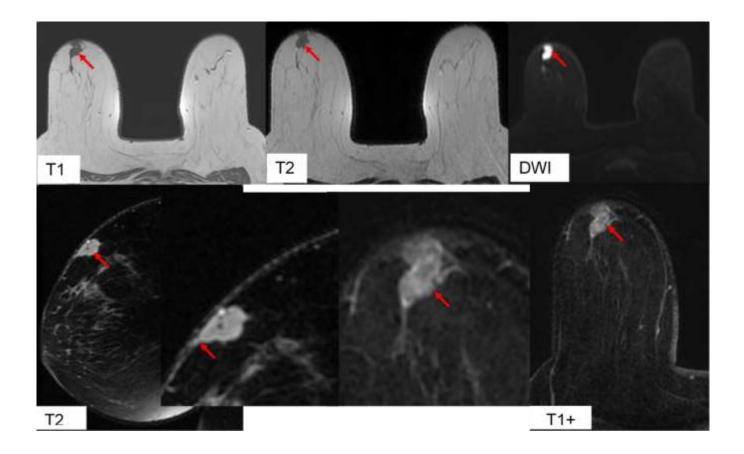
Breast MRI showing a suspicious lesion in hyposignal T1 hypersignal T2 intermediate, restrictive in diffusion, which rises heterogeneously, with extension to the skin covering.
